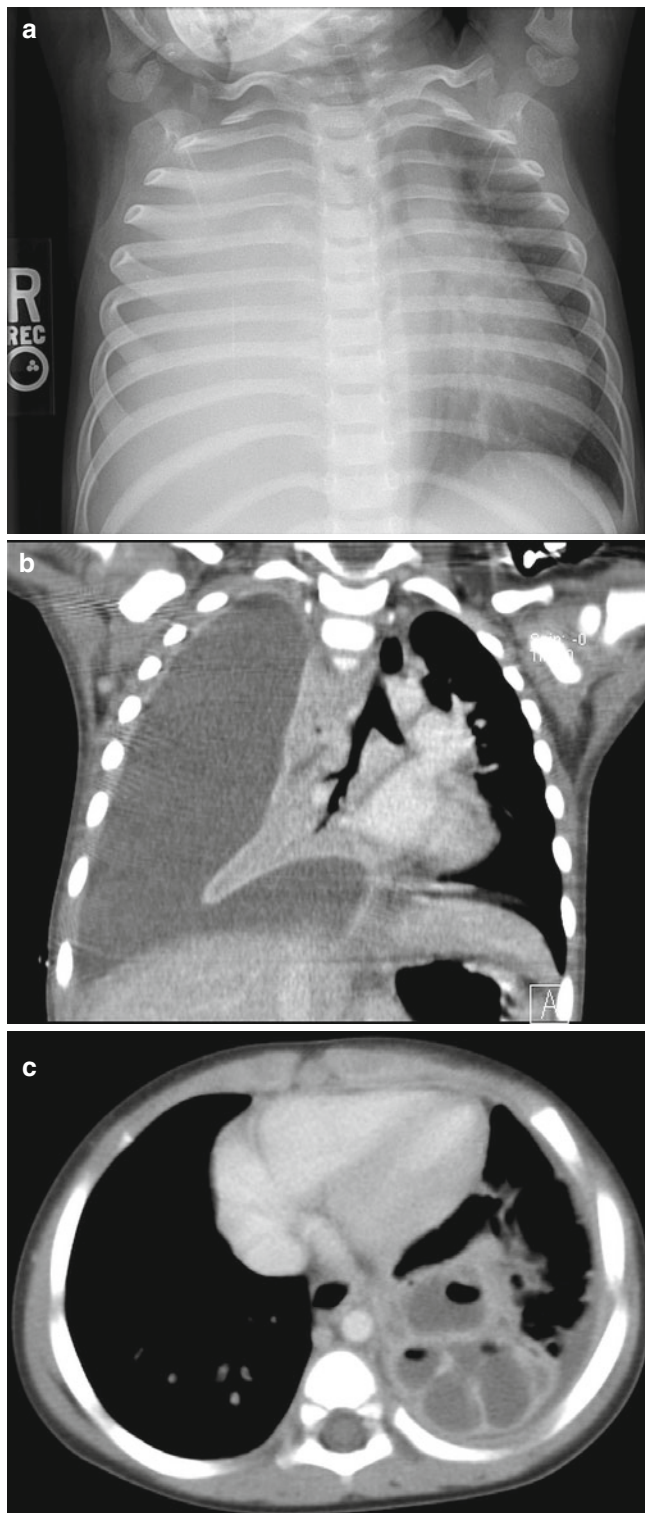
Effusions and empyema. (a, b) A CXR shows complete opacification of the right hemithorax, with significant mediastinal shift to the left. The corresponding chest CT demonstrates a large right pleural effusion occupying the entire right hemithorax associated with leftward mediastinal shift. (c) A lobulated and loculated fluid collection with air-fluid levels is present in the left lower lobe measuring 4.5×4.4 cm with enhancing septations
